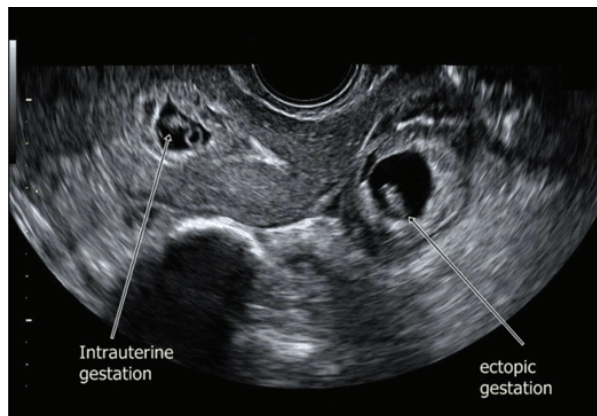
2 gestational sacs in ultrasonography of heterotopic pregnancy
